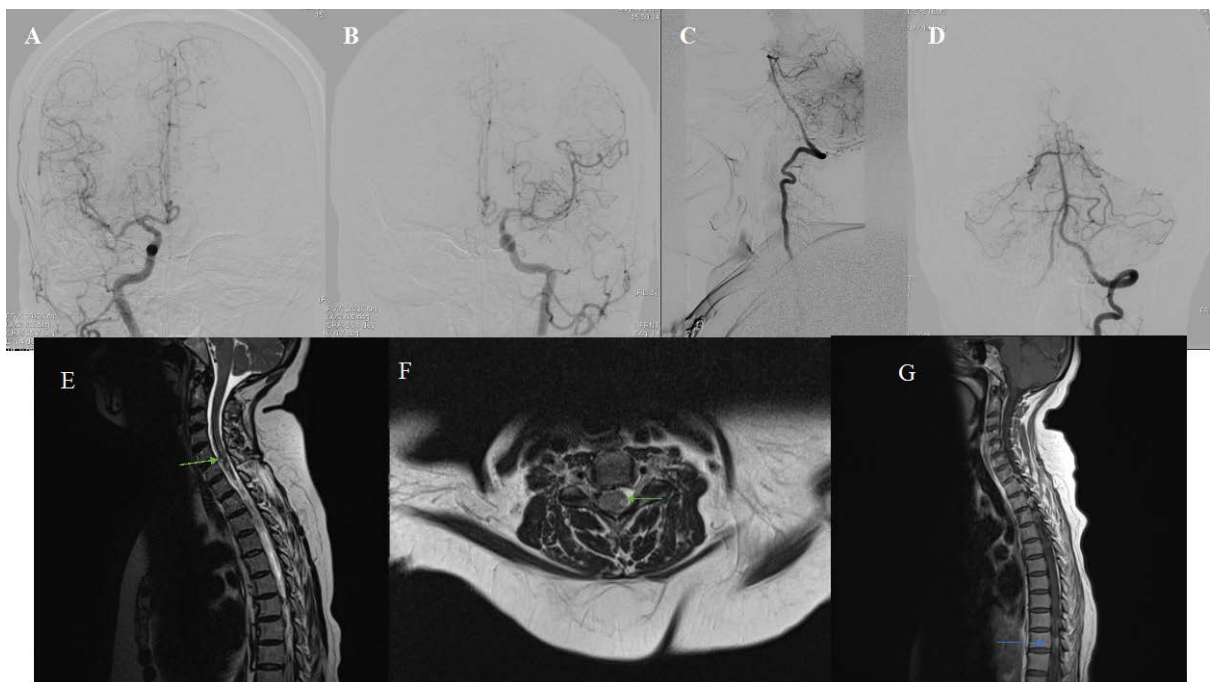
A- D shows initial normal angiogram with follow up MRI spine showing small extramedullary lesion at C6 (green arrow) and D11 levels (blue arrow)
